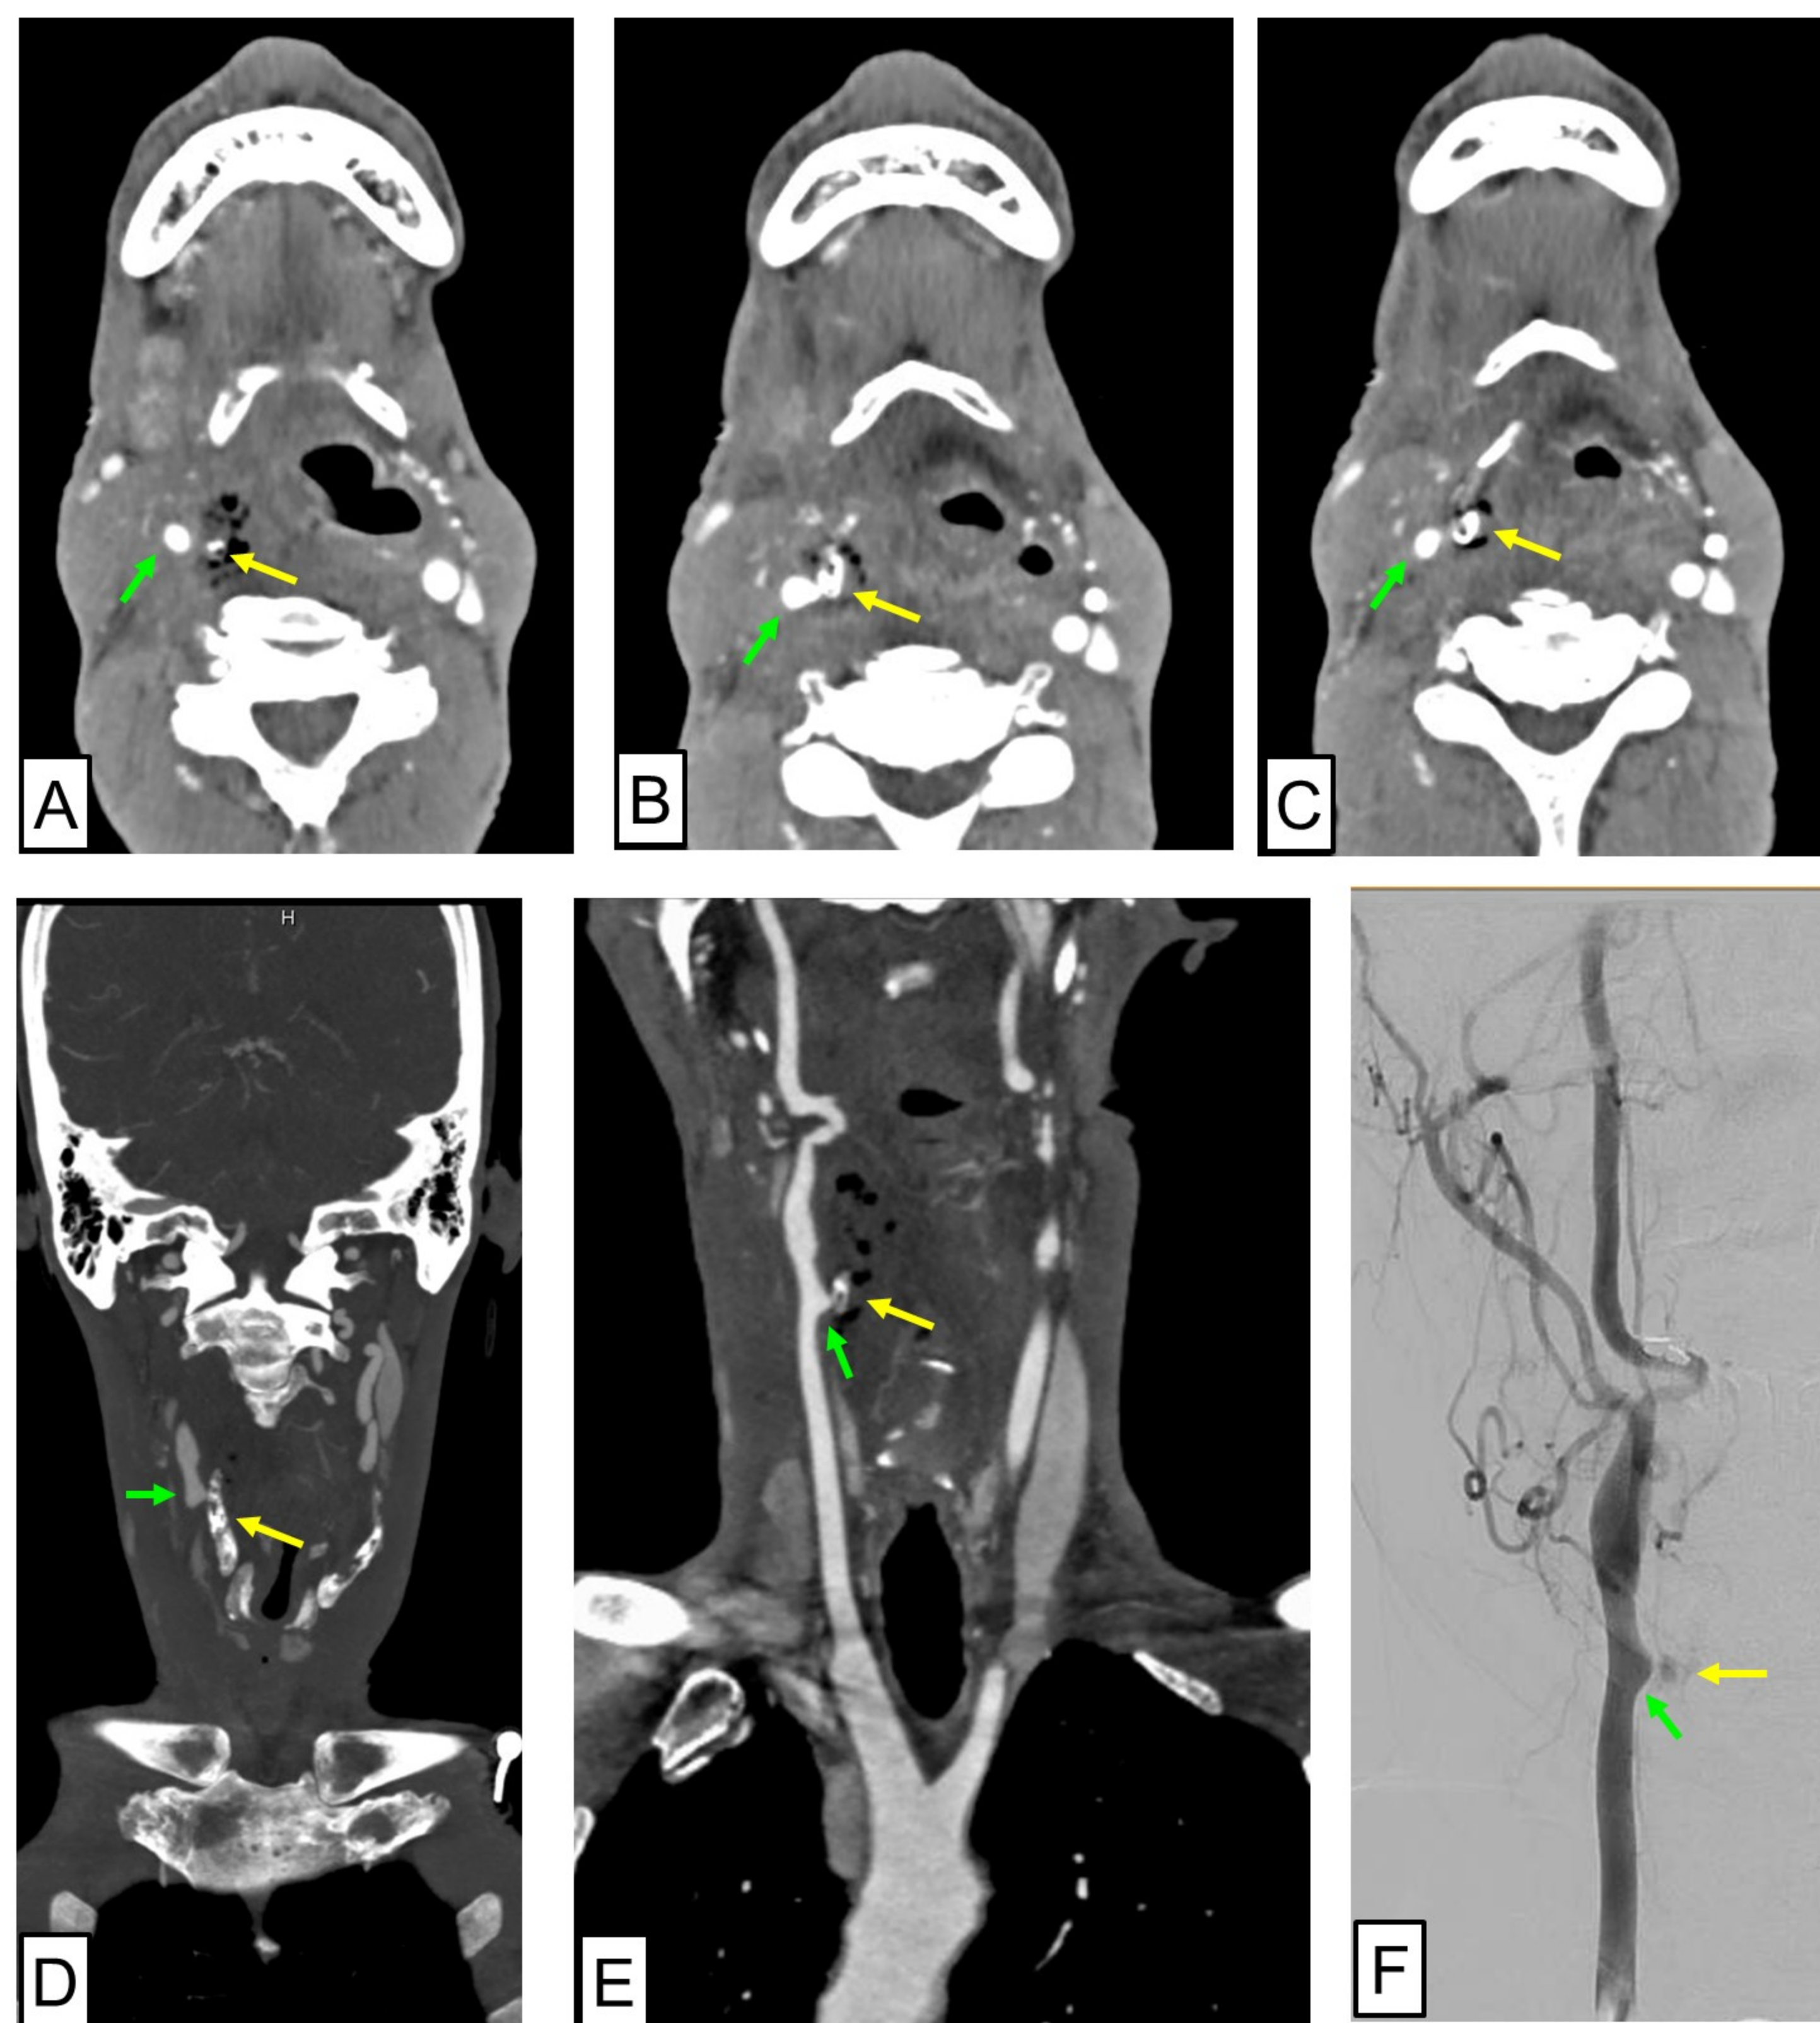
Radiographic findings in chondroradionecrosis and carotid blowout. A-C) CT Angiogram, axial view. The superior horn of the right thyroid cartilage has surrounding soft tissue edema and emphysema (yellow arrow). Note the proximity of the right common carotid artery (green arrow). D-E) CT Angiogram, coronal view. The superior horn of the right thyroid cartilage has a fragmented appearance (yellow arrow). Note the pseudoaneurysm of the common carotid artery in contact with the cartilage (green arrow). F) Angiography of the right common carotid system. Note the pseudoaneurysm of the common carotid artery (green arrow) just proximal to the bifurcation and the extravasation of contrast medially, representing active bleeding (yellow arrow).
